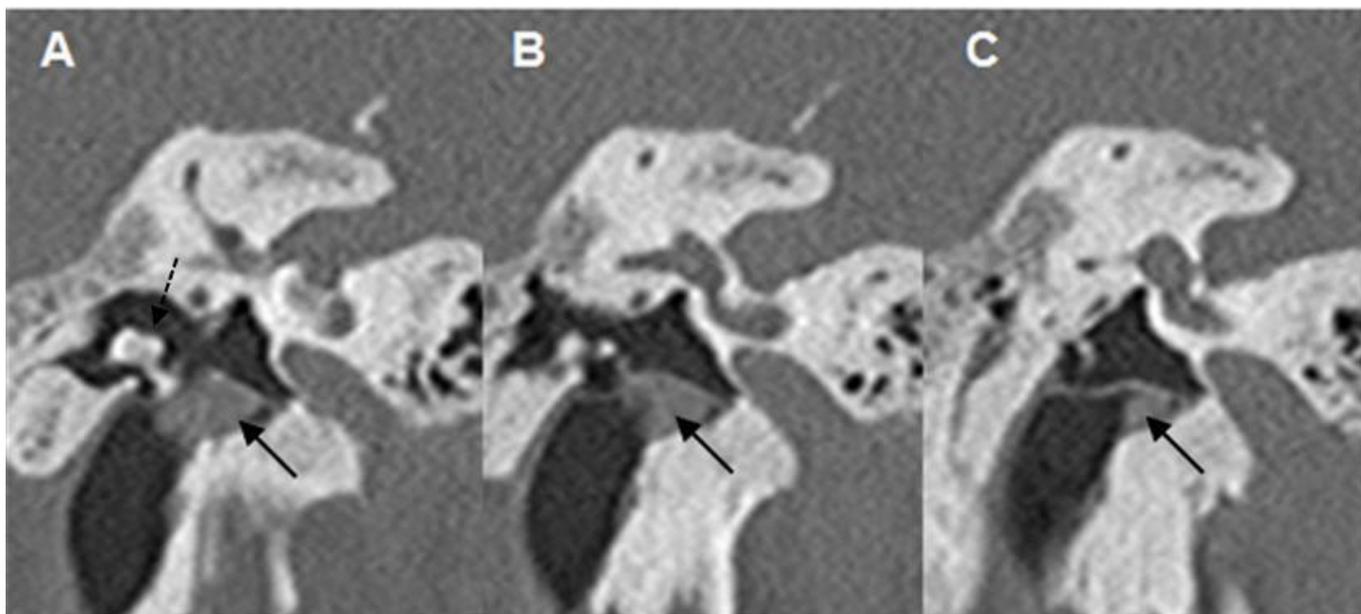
A-C: Serial coronal CT - images (slice thickness 1mm, native, 120kv/120mAs) of the right middle ear cavity in a 46 year-old man with hemifacial microsomia) shows dysplasia and partial fusion of the malleolus and incus within a small middle ear cavity (black dotted arrow in A). Soft tissue mass in front of the tympanic membrane (black arrows).
